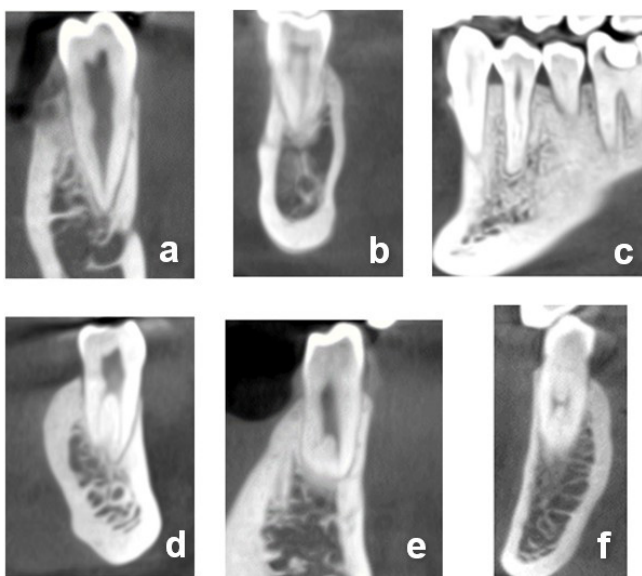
Examples of different sections of CBCT images showing Vertucci's root canal configuration in mandibular premolars (a. Type I, b. Type II, c. Type III, d. Type IV e. Type V and Type VI)
